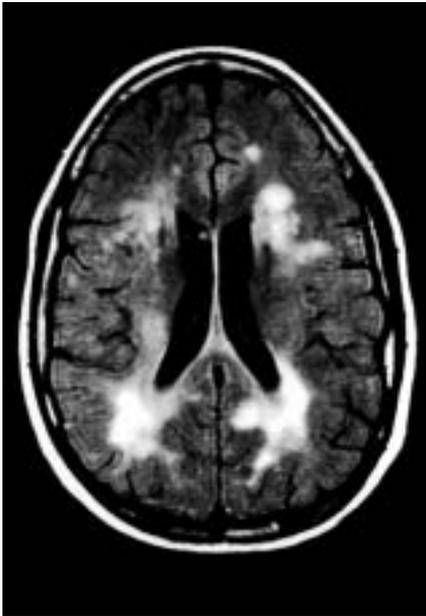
Head MRI (FLAIR) image of a patient with multiple sclerosis: multiple high-density areas are observed in the white matter around the lateral ventricles.
